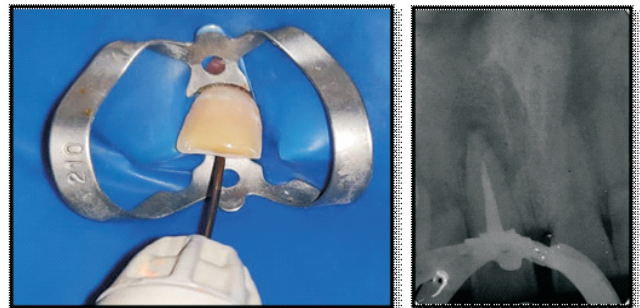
Intraoperative and Radiographic picture depicting obturation
